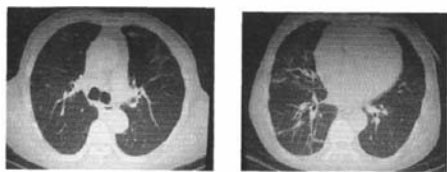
Chest CT on June 22, 2009 revealing the shadows in bilateral lung fields were absorbed obviously after therapy, with irregular cord shadow left
